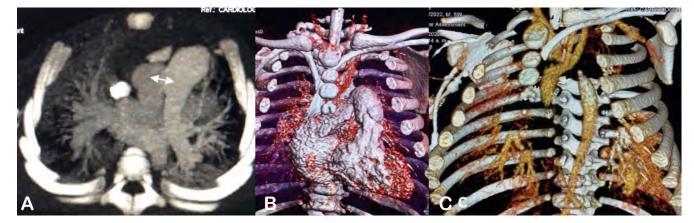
CT Angiography of the heart and great vessels; a) axial cut showing aortopulmonary window (white arrow), b) dilated 3D pulmonary reconstruction, c) reconstruction of the aortic arch showing interruption of the type A aortic arch, after emergence of the subclavian artery.
